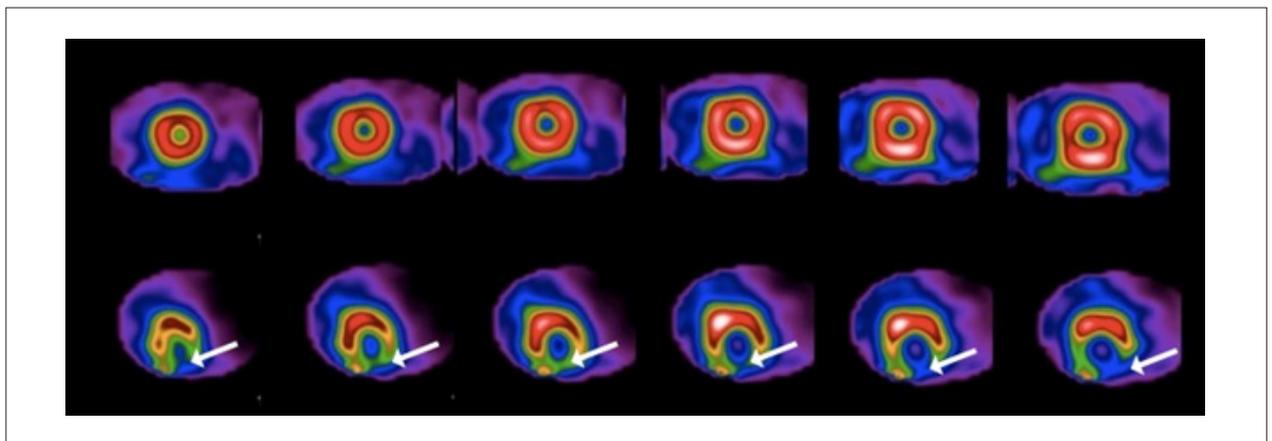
Cintilografia cardíaca com mIBG-I123 (fileira inferior) e de perfusão miocárdica com sestamibi-Tc99m (fileira superior). As imagens SPECT do curto eixo mostram um padrão *mismatch* entre perfusão/inervação simpática do miocárdio ventricular esquerdo, com perfusão normal e hipocaptação acentuada do mIBG-I123 nos segmentos apicais, inferiores e inferolaterais (setas), sugestivo de tecido miocárdico denervado nestas regiões. Fonte: Acervo pessoal dos autores.
